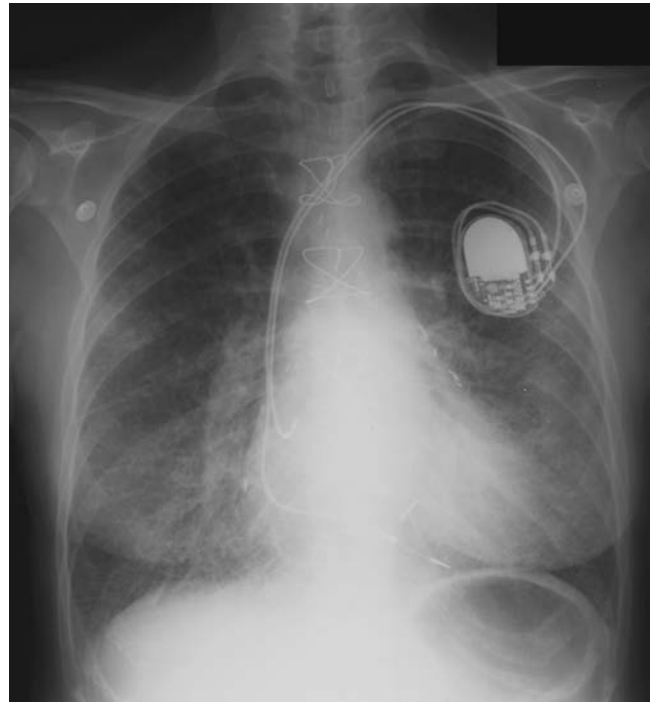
• The Patient's Chest Radiograph on Admission. A pacemaker and evidence of previous sternotomy are clearly seen. The heart is enlarged. There is a diffuse bilateral infiltrate with Kerley B lines (predominantly at the right base). The appearances are consistent with pulmonary edema.
